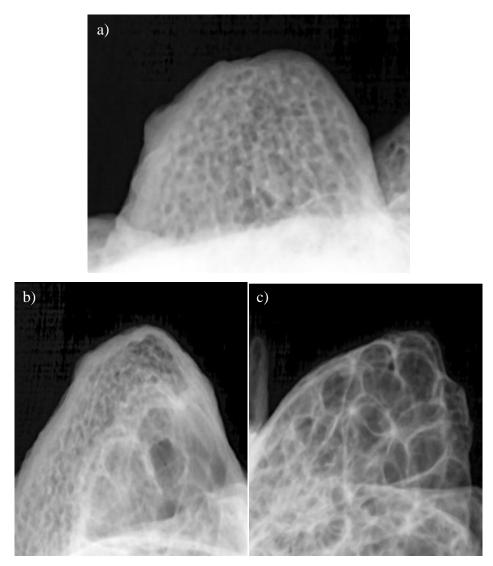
Images from the NOMAD Pro x-ray generatorraph: a) Shamanka II 24.1, right, no mastoiditis (a healthy mastoid with relatively homogeneous diplöe); b) Shamanka II 63.1, right, mastoiditis (diplöe beginning to be pneumatised); c) Shamanka II 49.1, left, mastoiditis.
